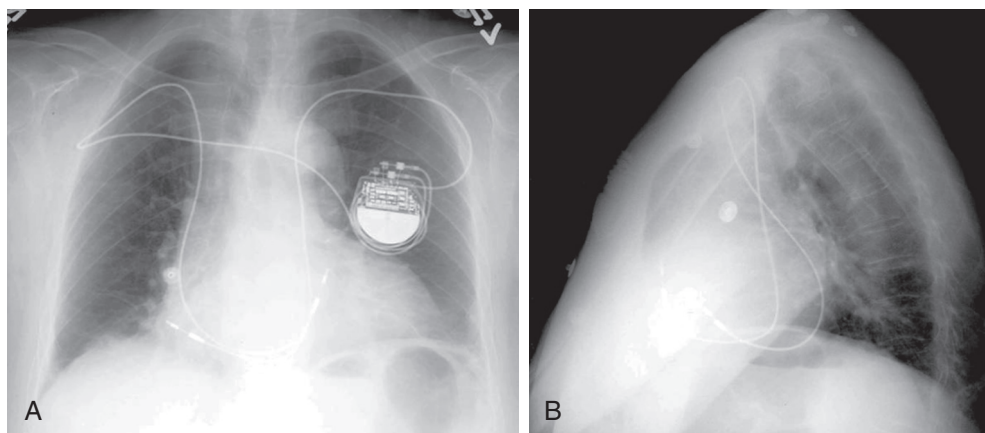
FIGURE e15-11 Chest radiographs of a 62-year-old woman with two pacemakers—the left-sided pacemaker implanted because of failure of the right. As seen on the frontal (A) and lateral (B) views, the right-sided wire traverses the right SVC and right atrium, and its tip lies superiorly and anteriorly in the pulmonary outflow tract. The left-sided wire traverses a persistent left SVC (a normal anatomic variant), and the coronary sinus and its tip, the lower of the two, is in the right atrium.
